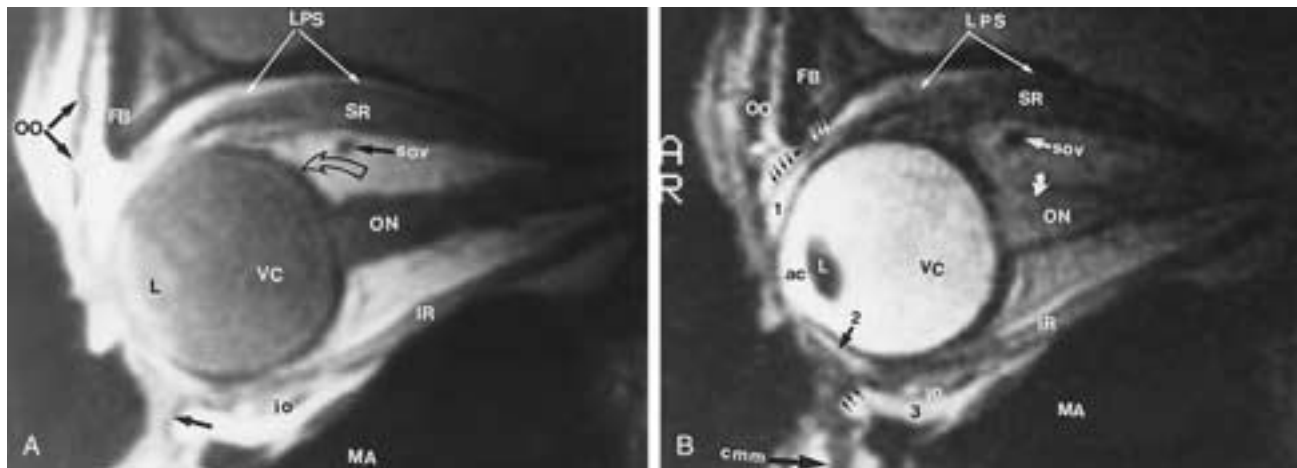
A, Normal MR imaging anatomy. Sagittal PW MR image shows fibers of the orbicularis oculi (OO); frontal bone (FB); levator palpebrae superioris (LPS); superior rectus muscle (SR); superior ophthalmic vein (SOV); sclera and Tenon capsule (*curved arrow*); optic nerve (ON); inferior rectus muscle (IR); maxillary antrum (MA); inferior oblique muscle (io); vitreous chamber (VC); lens (L); and orbital septum (*straight arrow*). B, Sagittal T2-weighted MR image shows fibers of the orbicularis oculi (OO); frontal bone (FB); levator palpebrae superioris (LPS); superior rectus muscle (SR); superior ophthalmic vein (SOV); optic nerve (ON); CSF along the optic nerve (*curved arrow*); inferior rectus muscle (IR); maxillary antrum (MA); inferior oblique muscle (io); extraconal fat (3); orbital septum (*three small arrows*); complex muscle of mouth (cmm); inferior (2) and superior (1) fornices; anterior chamber (ac); lens (L); and vitreous chamber (VC). Note the tendon of insertion of the levator palpebrae superioris (*small white arrows*). This tendon is an aponeurosis that descends posterior to the orbital septum. The orbital septum is depicted in this section as an ill-defined image (*arrowhead*). The tendinous fibers of the superior palpebrae muscle pierce the orbital septum and become attached to the anterior surface of the superior tarsal plate (*four black arrows*).
